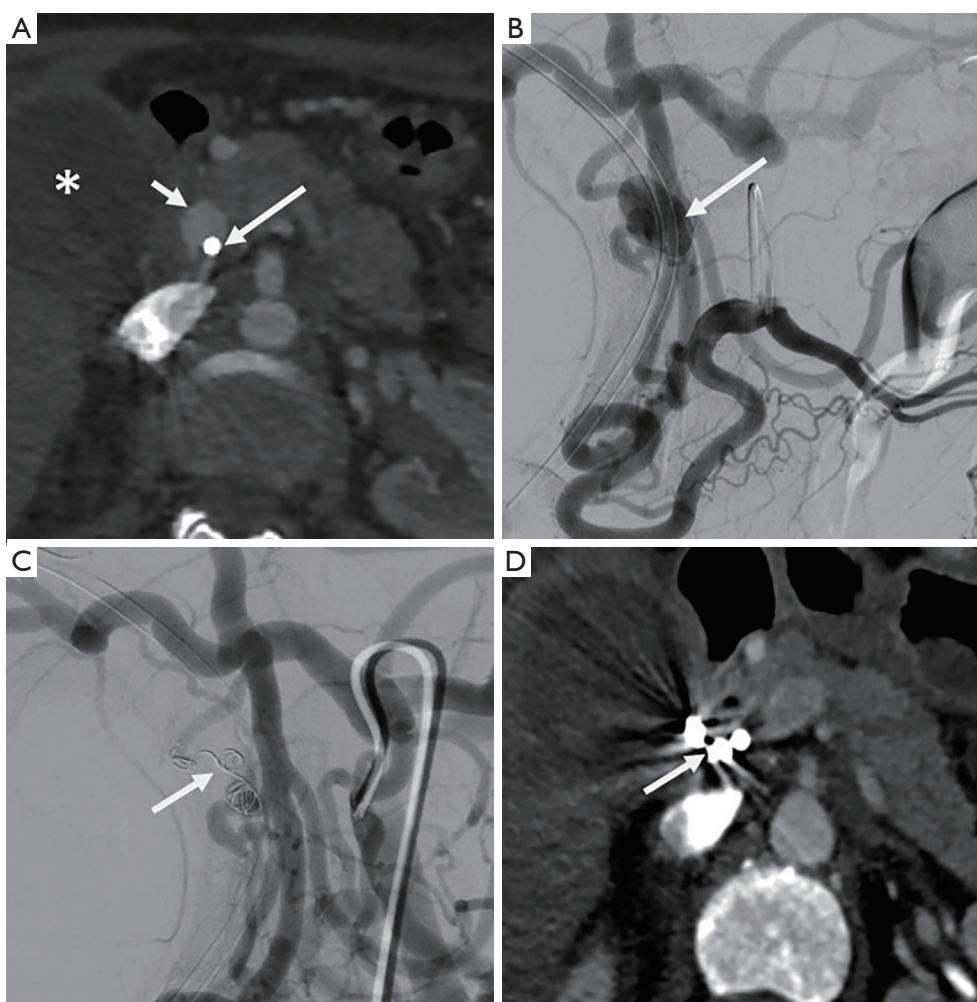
A 35-year-old female referred for haematemesis in a context of metastatic breast cancer. The patient had main bile duct extrinsic compression due to peritoneal carcinosis, with endoscopic placement of plastic stent in the main bile duct. (A) Abdominal CT showing a 12×12 mm VAPA in the main bile duct (short arrow) in contact with the plastic stent (long arrow), without active bleeding, but blood in the gallbladder (star). (B) Angiogram using Side probe in the SMA confirmed VAPA (arrow), with retrograde flow due to median arcuate ligament. (C) The feeding artery was occluded by back door/front door method using 1 fibered coil (arrow). (D) Control CT angiogram showing complete occlusion of the VAPA and artifacts of coils (arrow). CT, computed tomography; VAPA, visceral artery pseudoaneurysm; SMA, superior mesenteric artery.
